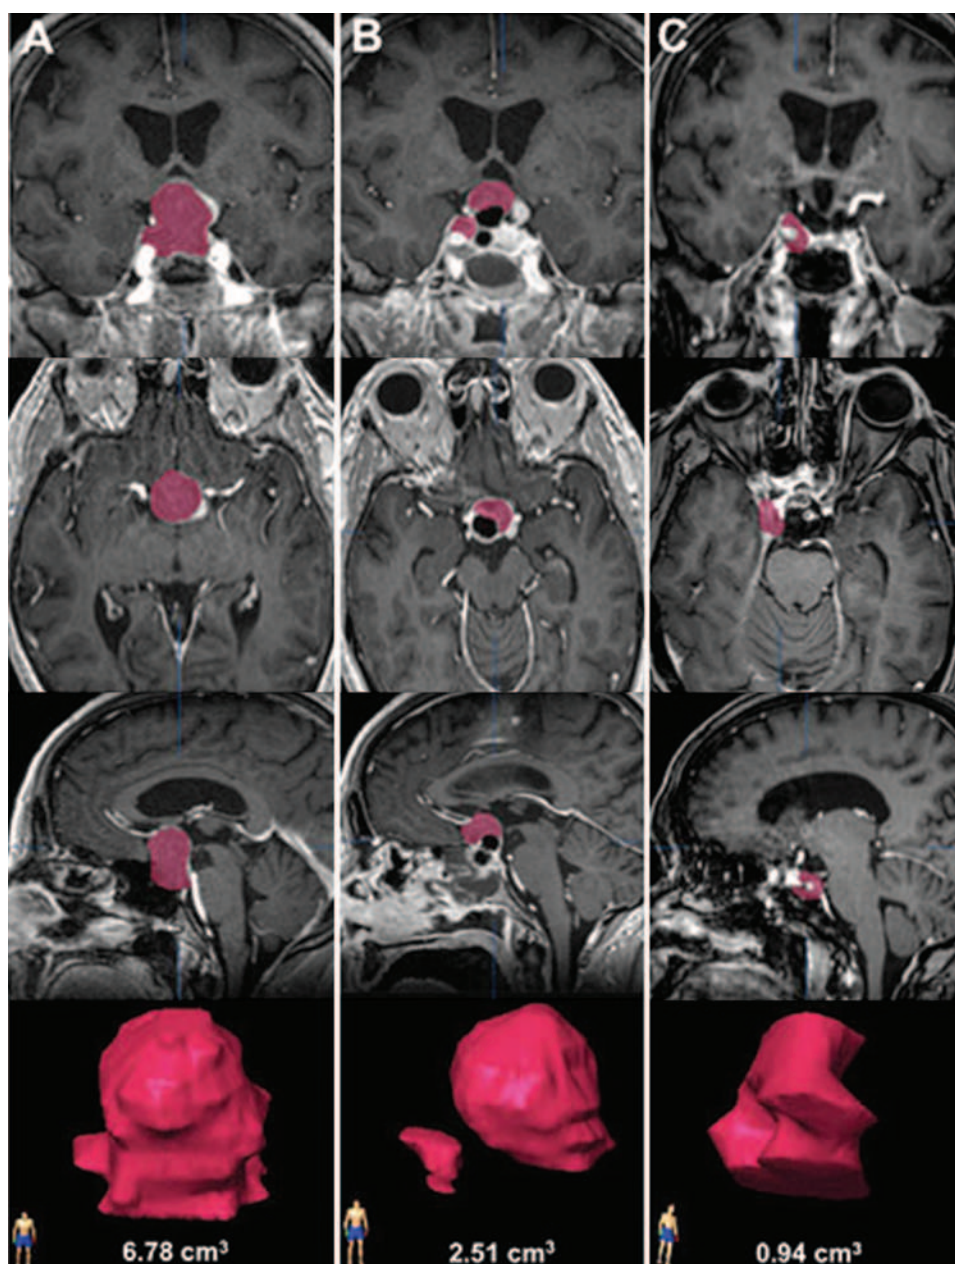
Volumetric segmentation of adenoma volume on the preoperative (A), intraoperative (B), and postoperative (C) MRI.
